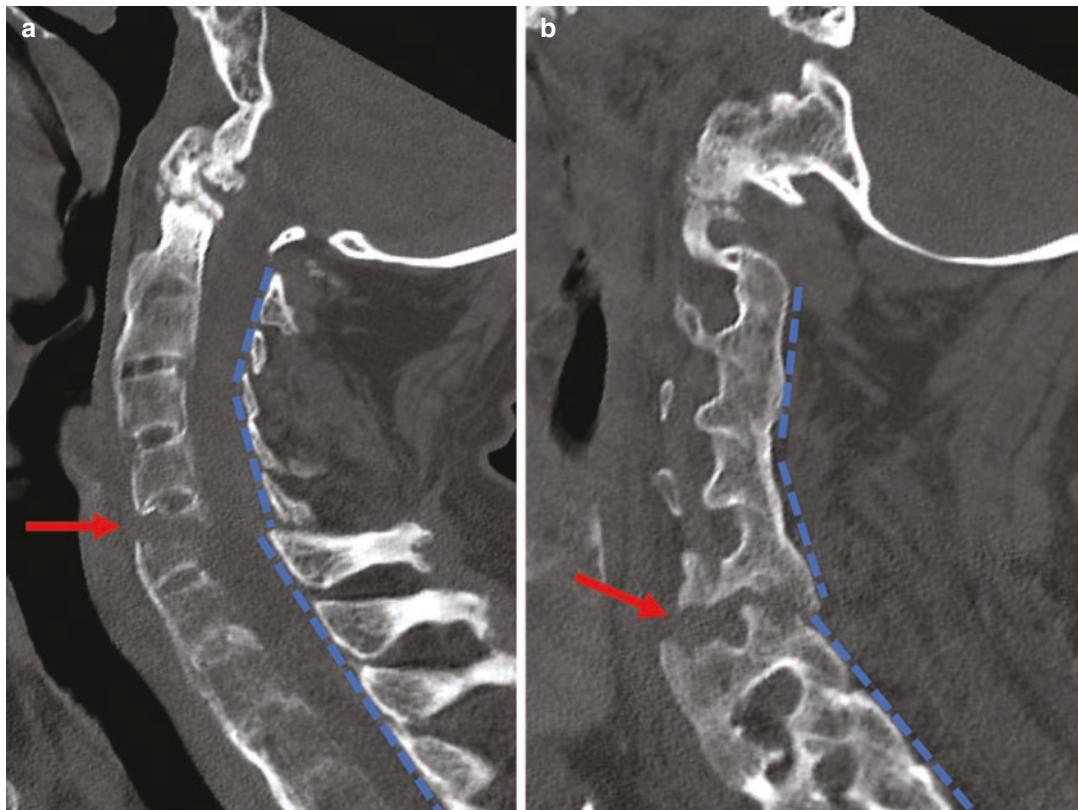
Extension fracture dislocation in a 62-year-old man with ankylosing spondylitis. (a) Sagittal and (b) parasagittal CT cervical spine images show a fracture through an anterior bridging osteophyte and a fused facet
